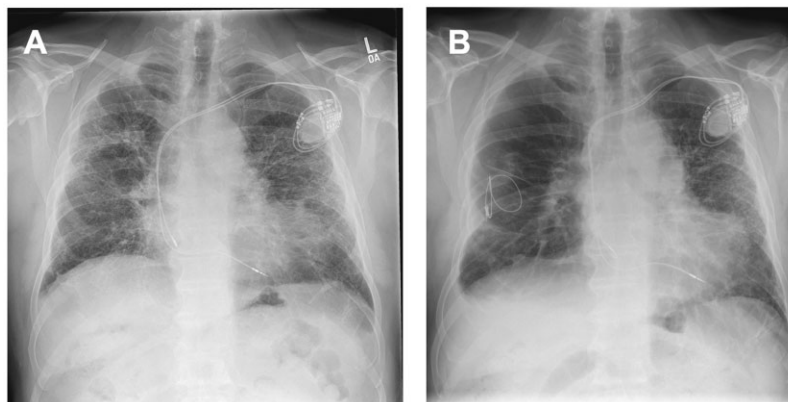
(A) Chest X-ray pre-lung transplantation. (B) Chest X-ray post-lung transplantation showed rotation of the heart within the thorax.
